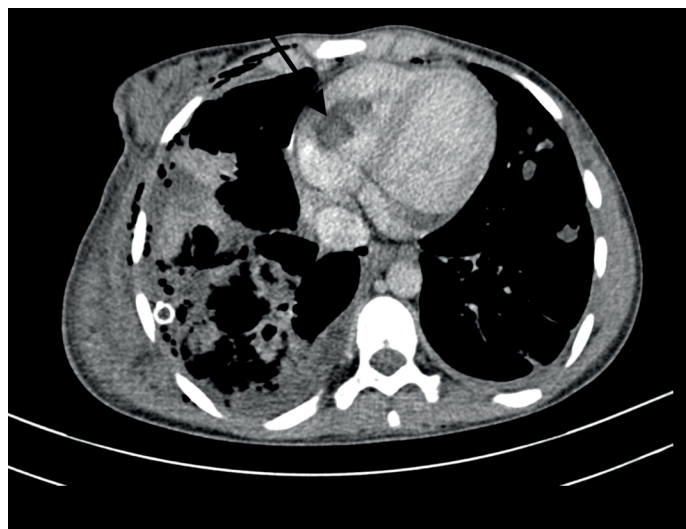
Contrast enhanced thorax CT
